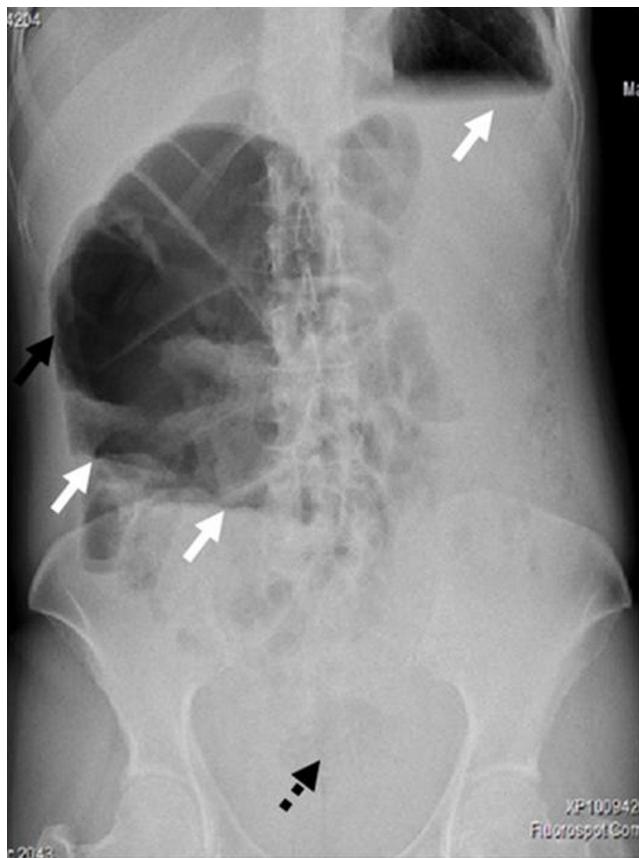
Simple standing X-ray of the abdomen with caecal dilation (black arrow), hydro-aereo levels (white arrows) and absence of air in the rectal ampule (discontinuous black arrow).
